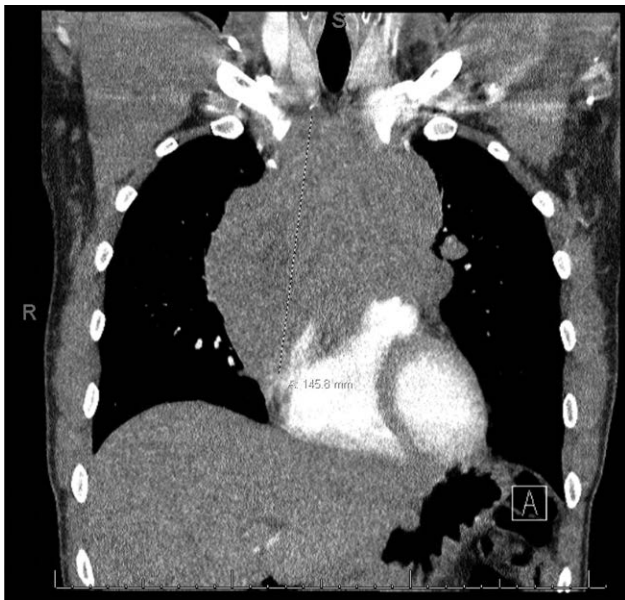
Computed tomography of the chest with intravenous contrast in the coronal plane with largest dimension (14.6 cm) of the mass delineated.
